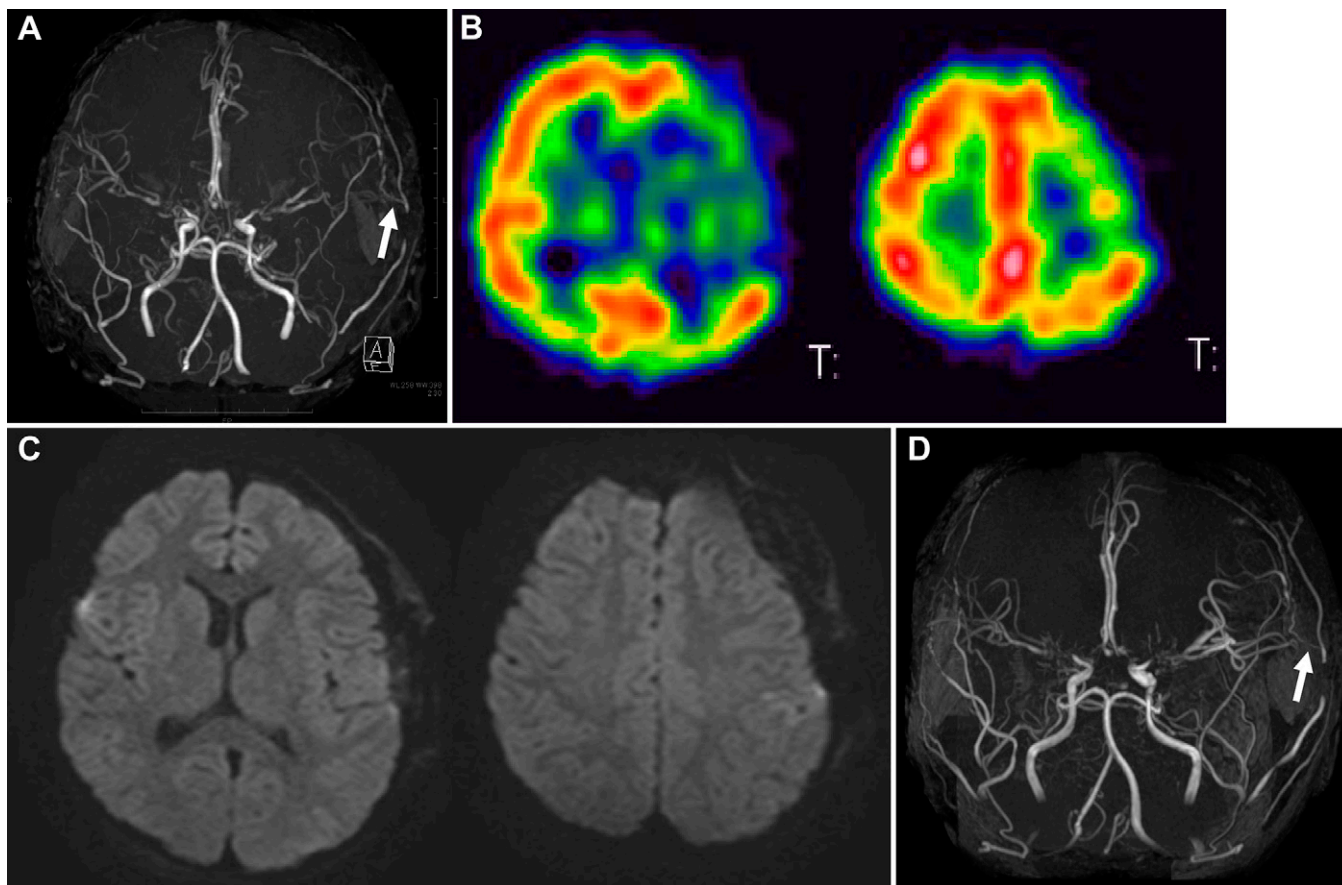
Left cerebral revascularization, consisting of STA-MCA single bypass plus encephalo-myo-synangiosis of the temporal region and encephalo-galeo-periosteal-synangiosis of the frontal region, was performed via two craniotomies. The patient developed motor aphasia and right upper limb aphasia immediately after surgery. A: MRA from POD 1 shows the patent bypass (*arrow*). B: SPECT on POD 3 shows extensive CBF decreases in the left MCA territory. C: MRI/MRA reexamination on POD 4 shows no acute cerebral infarction, and the bypass remained patent (D, *arrow*).
